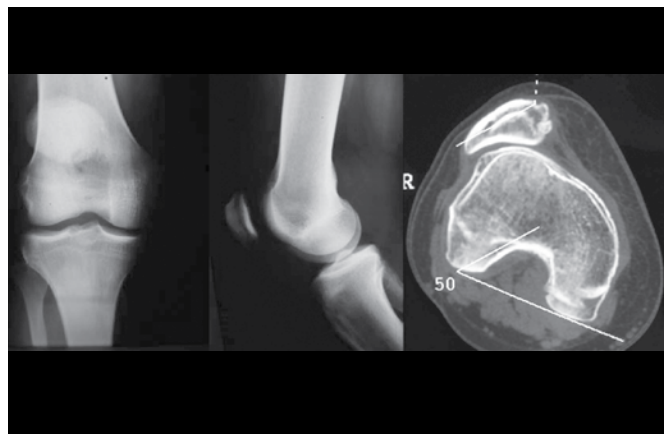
Radiological exam and computed tomography of a 25-year-old male patient, with objective patellofemoral instability in the right knee, with trochlear dysplasia classified as type C, increased patellar tilt and above normal patellar height.
